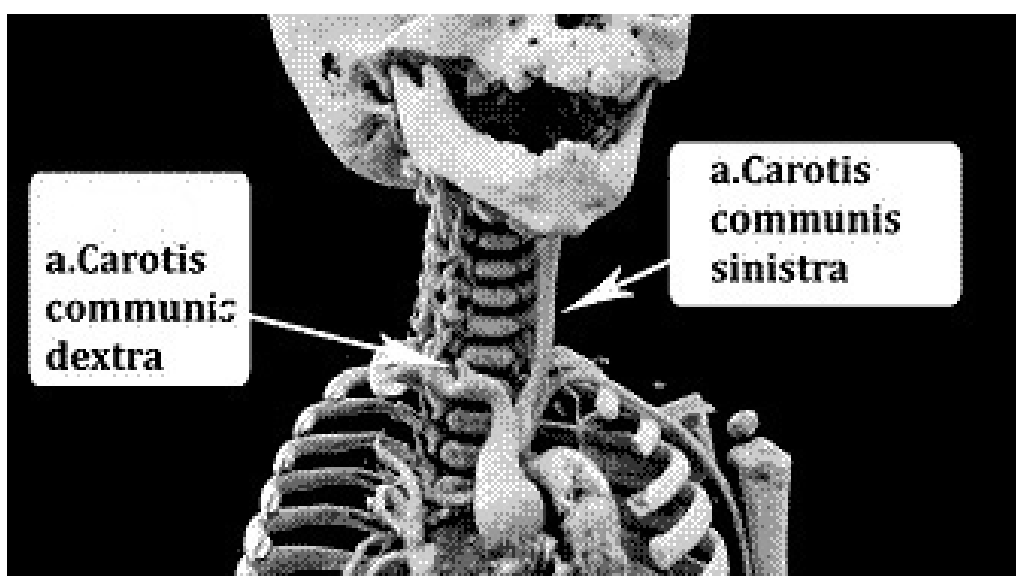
Computed tomography of the neck vessels with 3D reconstruction
